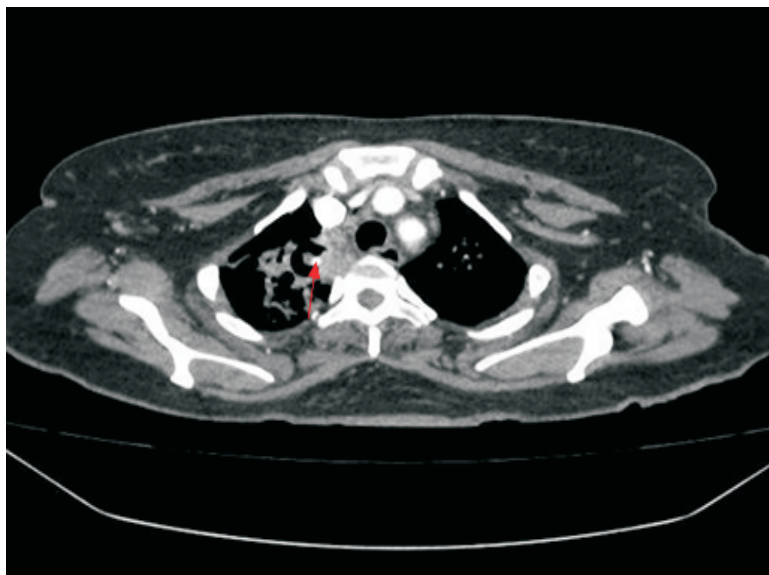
Contrast Enhanced Computed Tomography of the lung image showing Rasmussen aneurysm.
